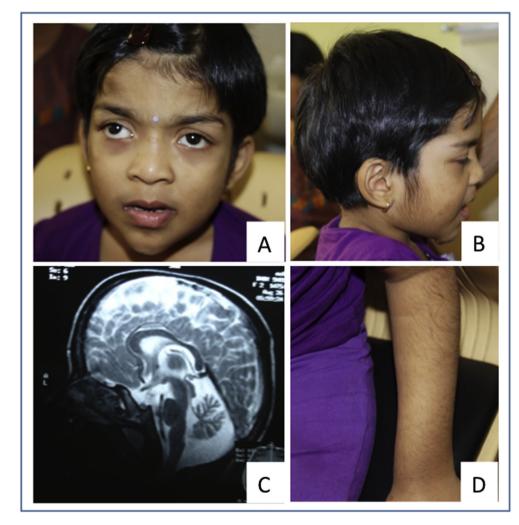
Subject at age 6 years and nine months. Note the telecanthus, strabismus, puffy eyelids, long and deep philtrum, broad bridge and base of nose, thick vermillions of upper and lower lip, pointed chin (A) and increased facial and body hair (B,D). Magnetic resonance imaging of brain shows cerebellar atrophy with normal brainstem structures (C).
